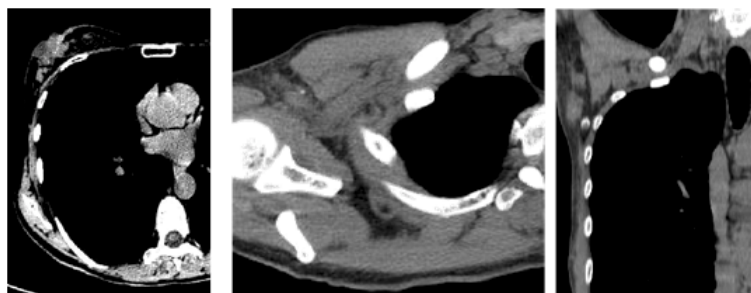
Computed tomography -invasive carcinoma NST of the right breast with large calcifications into the tumor and lymph nodes
